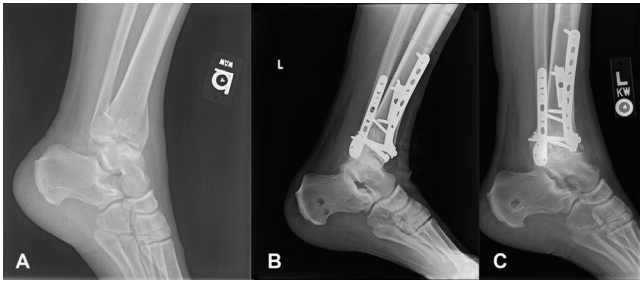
(A) A lateral radiograph showing left pilon fracture with anterior impaction, (B) An immediate postoperative lateral radiograph showing anterolateral primary plate and accessory anterior rim plate; (C) A two-year postoperative lateral radiograph showing anterior talar subluxation, anterior plafond avascular necrosis and post-traumatic tibiotalar arthrosis.
